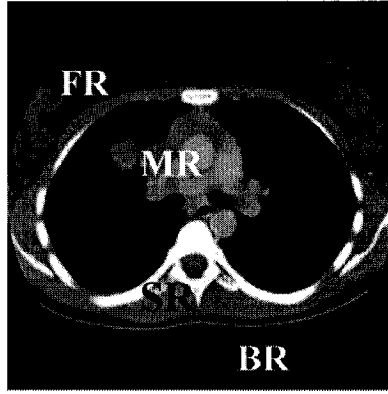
Pathological modelling for chest CT scans. The chest CT image can be divided into four regions:  $\Omega_{FR}$ ,  $\Omega_{MR}$ ,  $\Omega_{SR}$ , and  $\Omega_{BR}$ .
